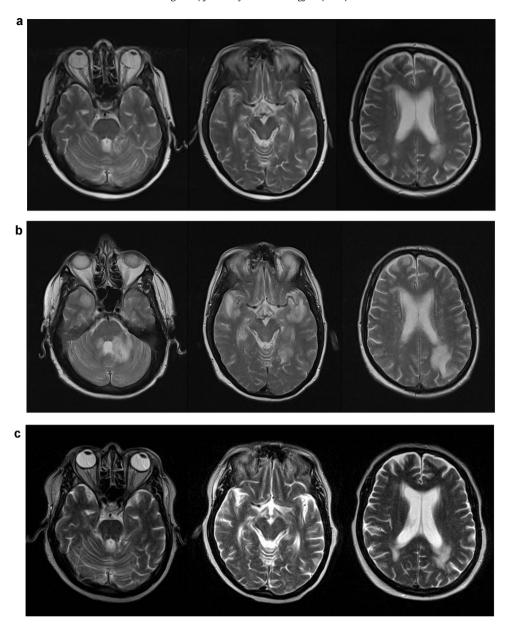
MR images of the brain during course of illness. (a) Initial presentation with dysphagia in April 2010 (T2-weighted). (b) Admission with right leg weakness in July 2010 (T2-weighted). (c) After six months of treatment with ganciclovir, January 2011 (T2-weighted turbo spin-echo). There was extension of high signal intensity in the left medulla and left occipital lobe in July 2010 with new changes in both temporal lobes, left subinsular cortex and right frontal lobe. These changes resolved with clinical recovery.
